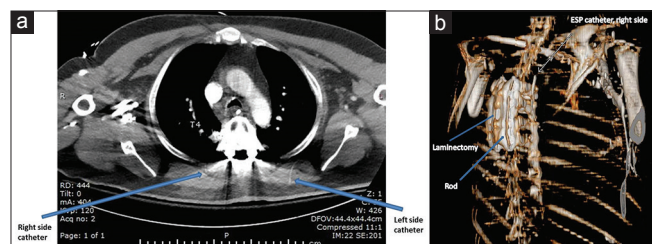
(a) T4 level showing both right and left ESP catheters in the correct position. (b) 3D CT scan showing missing lamina/spinous process. Right ESP catheter and hardware can be visualized as well
